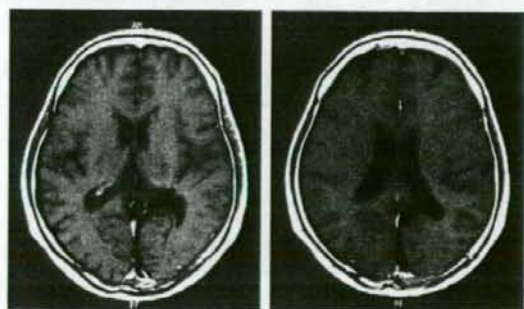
Left and right: Postoperative gadolinium-enhanced T1-weighted images demonstrating the route approaching the left trigone from the interhemispheric fissure and confirming complete removal of the tumor.
